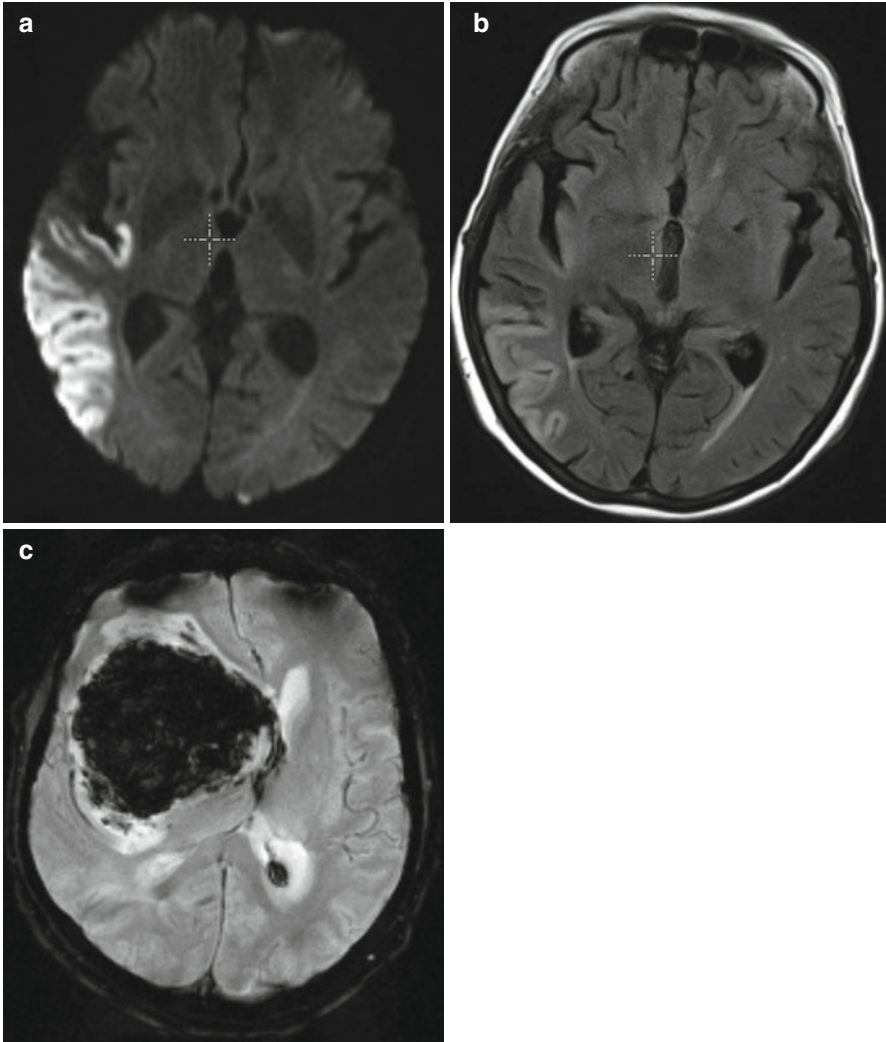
(a) Ischemic stroke in DWI-Imaging. (b) Ischemic stroke in FLAIR Imaging. (c) In comparison hemorrhagic stroke in t2* weighted image
